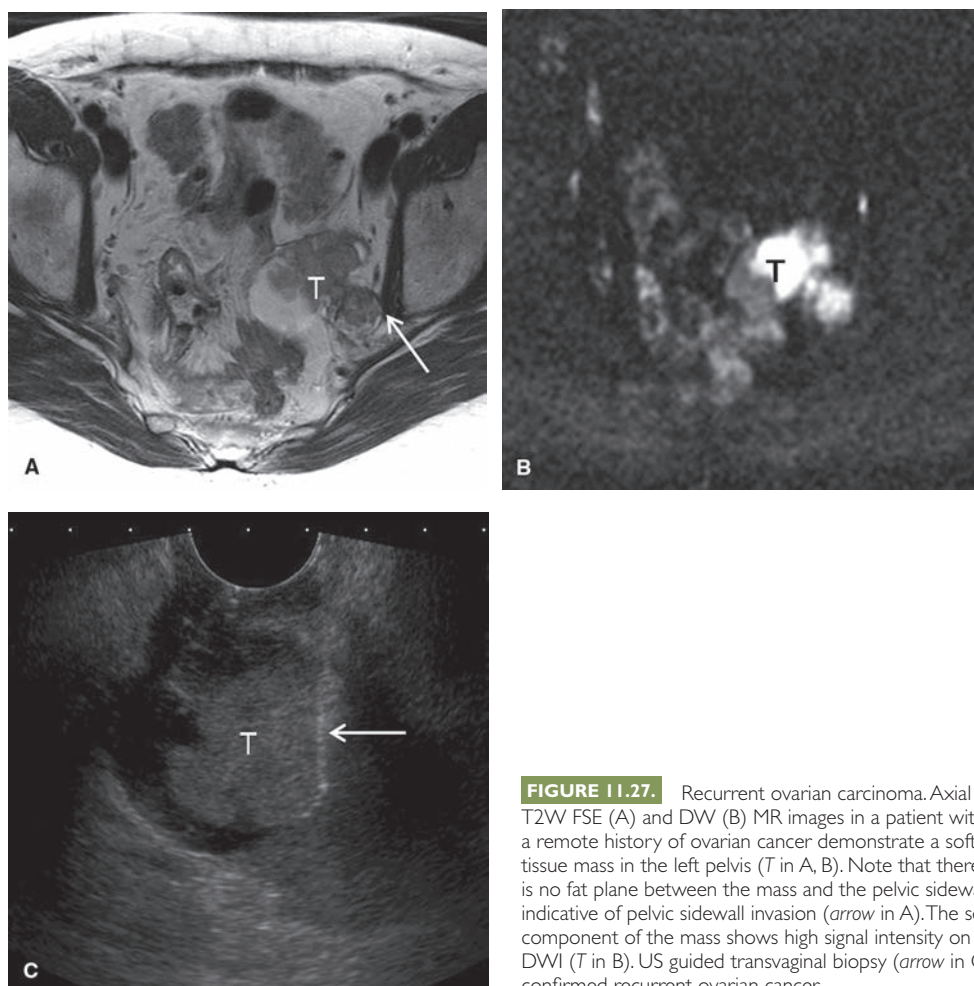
Recurrent ovarian carcinoma. Axial T2W FSE (A) and DW (B) MR images in a patient with a remote history of ovarian cancer demonstrate a soft tissue mass in the left pelvis (T in A, B). Note that there is no fat plane between the mass and the pelvic sidewall, indicative of pelvic sidewall invasion (arrow in A). The solid component of the mass shows high signal intensity on DWI (T in B). US guided transvaginal biopsy (arrow in C) confirmed recurrent ovarian cancer.
